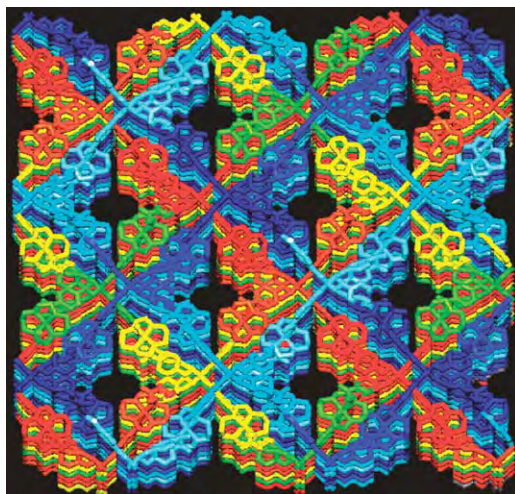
X-ray structure of 14. The 8-fold interpenetrating diamondoid networks in the [4+4] mode, which generate 1D channels (effective window size, $4.7 \times 6.7 \text{ \AA}^2$).
